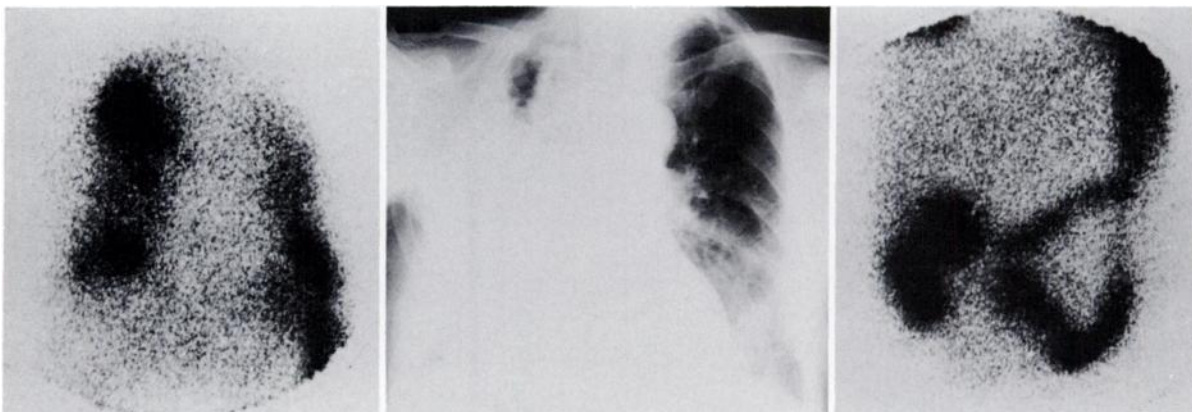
Images from patient with an infected cavitating right-upper-lobe bronchial carcinoma who received "mixed" cells labelled with In-111 tropolonate. Abnormal activity is seen on 24-hr anterior chest image (left), especially in right upper, right lower, and left lower zones. On dynamic imaging, labelled cells were not retained in lung following injection, although at 40 min the count rate over right upper zone was increasing. Other areas abnormal at 24 hr were clear at 40 min, with static count rates. Splenic activity is also visible but there is minimal liver uptake. Chest radiograph is also shown (center). Extensive abnormal activity is seen in bowel at 48 hr (right), reflecting swallowed granulocytes.
